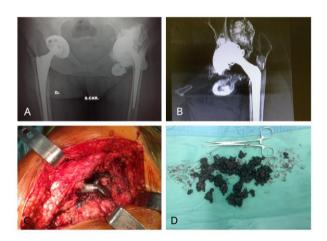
Preoperative radiograph (A): large and irregular joint opacification from the trochanteric side to the femoral and inguinal area. Preoperative CT scan (B): lobulated pseudotumor with metallic density; Intra-operative view (C): extensive metallosis of periprosthetic tissues; Periprosthetic tissues (D): a dark jelly mass which was debrided until it was possible.
